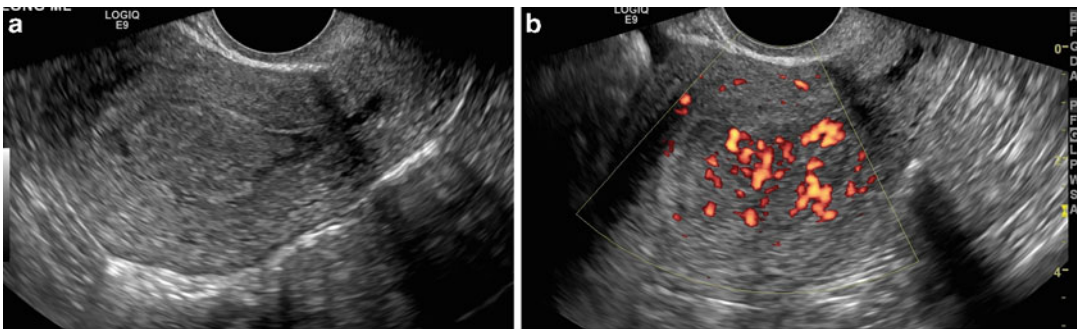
A 31-year-old woman with abnormal uterine bleeding and history of polycystic ovarian disease. Endovaginal sonographic images show abnormally thickened endometrium with increased blood flow seen on
